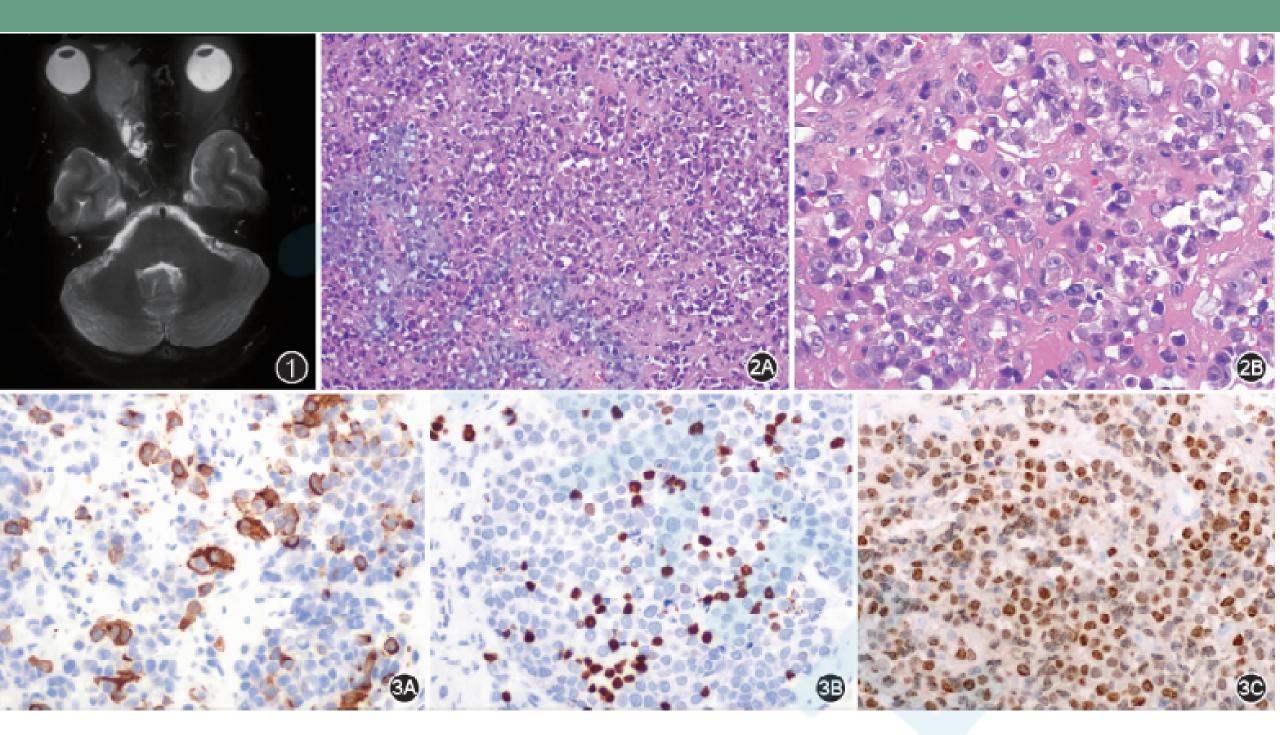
患者 MRI 表现,显示肿瘤呈侵袭性生长,破坏右侧眼眶内壁骨质 图2 NUT 中线癌的 HE 镜下表现; A 示肿瘤细胞由片状或 巢状排列的低分化或未分化细胞构成 HE 中倍放大; B 示肿瘤细胞的黏附性差,胞质较少,染色质细腻或呈颗粒状,核仁明显,核分裂象易见,胞质嗜酸性或透亮 HE 高倍放大 图3 NUT 中线癌免疫组织化学结果; A 示肿瘤细胞呈 AE1/AE3 的散在表达 EnVision 法 高倍放大; B 示散在的肿瘤细胞 p63 阳性 EnVision 法 高倍放大; C 示肿瘤细胞 NUT 弥漫核点状阳性 EnVision 法 高倍放大
